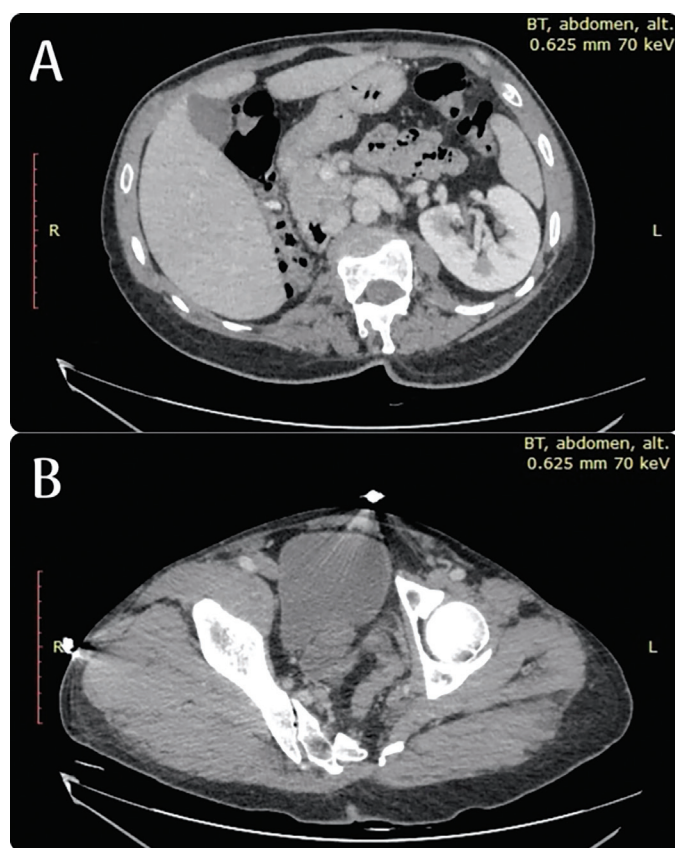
A. Preoperative post-contrast axial CT image of the right renal agenesis, B. Preoperative post-contrast axial CT image of the right seminal vesicle cyst
